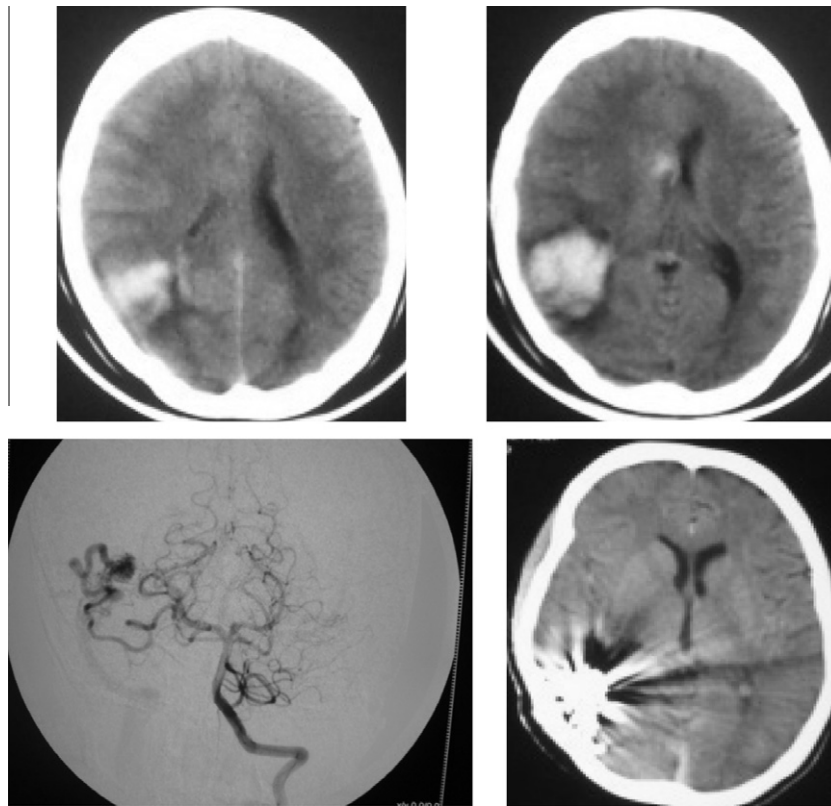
CT scan (axial view) showing spontaneous right parieto-occipital ICH in male child aged 15 years. CT scan (axial view) showing the mass effect of ICH in form of effacement of the right lateral ventricle. Conventional angiography showing right occipital AVM. CT scan (axial view) after endovascular embolisation of the AVM.
